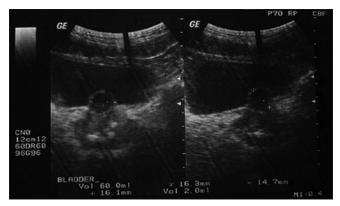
Ultrasound revealing a cyst at the level of the bladder neck and urinary retention
